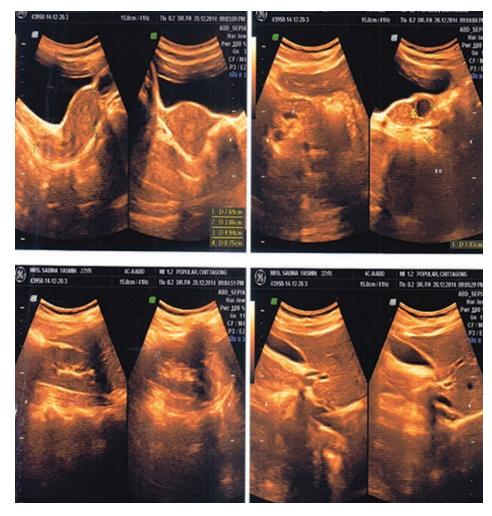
Ultrasonography of Lower Abdomen
